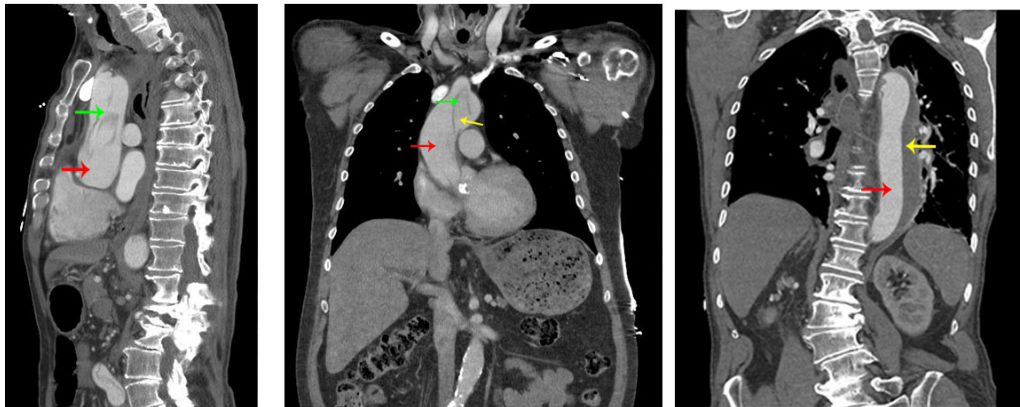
CT IMAGES FROM A PATIENT WITH ACUTE TAAD. THE RED ARROW INDICATES THE POSITION OF THE TRUE LUMEN, THE YELLOW ARROW INDICATES THE POSITION OF THE FALSE LUMEN AND THE GREEN ARROW SHOWS THE POSITION OF THE INTIMAL FLAP.
